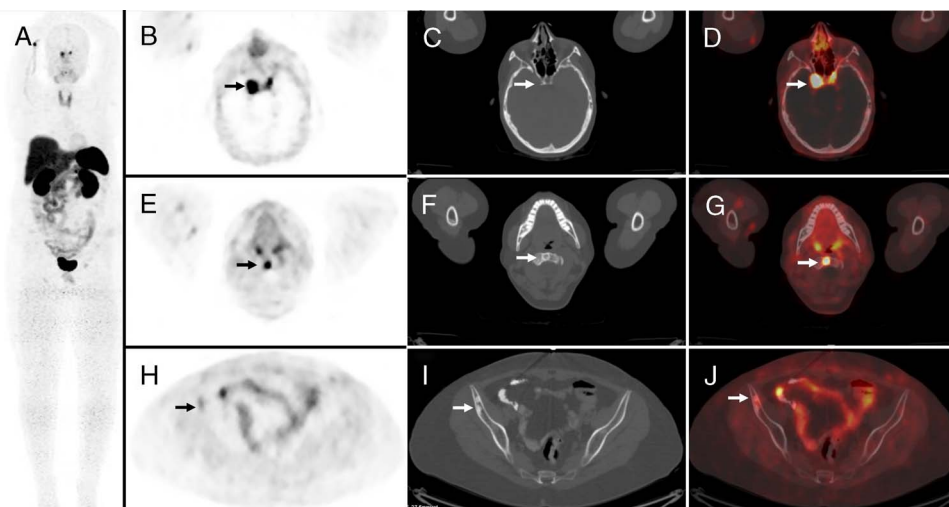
A 28-year-old woman diagnosed with adrenocorticotrophic hormone (ACTH)-secreting pituitary adenoma and treated with transsphenoidal resection 5 years ago was presented with complaints of headache and blurry vision. MRI showed a 2-cm diameter lesion filling the cavernous sinus in the right sellar area and a 7-mm diameter lesion in the left sellar area. ^{18}F -FDG PET/CT was performed to stage the disease. ^{18}F -FDG PET/CT did not show any evidence of local recurrence in the sellar area. ^{18}F -FDG PET/CT revealed multiple sclerotic lesions in the skeleton, but ^{18}F -FDG uptake was not observed in any of the lesions. The patient underwent ^{68}Ga -DOTATATE PET/CT to show the nature of the primary pituitary tumor and skeletal lesions. ^{68}Ga -DOTATATE PET/CT demonstrated intense ^{68}Ga -DOTATATE uptake in the sellar lesions (A, MIP image; B, PET image; C, CT image; D, PET/CT image). Moreover, ^{68}Ga -DOTATATE PET/CT revealed increased expression of somatostatin receptors in the skeletal lesions, which proves that these lesions were metastases of the pituitary tumor (arrows in E, PET image; F, CT image; G, PET/CT image; H, PET image; I, CT image; J, PET/CT image). Pituitary carcinomas are extremely rare tumors that account for only 0.2% of all pituitary neoplasms.¹ Pituitary carcinoma is described as a primary sellar tumor associated with aggressive intracranial lesions or metastasis to distant sites. Pituitary carcinoma is almost always diagnosed as a benign tumor in adults and requires a long time interval for progression to carcinoma. Ki-67 index, nuclear P53 expression, and mitotic figures have been used to determine tumor aggressiveness. However, none of these markers has been able to detect pituitary carcinoma at an early stage.² Pituitary carcinoma has a poor prognosis and shows rapid deterioration after the diagnosis, despite the urgent use of aggressive treatments.³ Brain MRI is not sufficient to diagnose pituitary carcinomas; therefore, the whole body must be examined to detect metastases. ^{68}Ga -DOTATATE PET/CT may become an alternative modality for screening pituitary carcinoma. ^{68}Ga -DOTATATE is a selective somatostatin analog with increased affinity for somatostatin receptor subtype 2 and has been routinely used for imaging neuroendocrine tumors.⁴ Pituitary adenomas express high somatostatin receptors and are well known to show high ^{68}Ga DOTATATE uptake. However, due to the rarity of pituitary carcinomas, there have been limited cases that show ^{68}Ga -DOTATATE uptake in these tumors.^{5–8} Furthermore, sclerotic skeletal metastasis showing ^{68}Ga -DOTATATE uptake has not been reported before. This unique case highlights the usefulness of ^{68}Ga -DOTATATE PET/CT in detecting metastasis of pituitary carcinoma, which is difficult to diagnose by conventional imaging methods.
